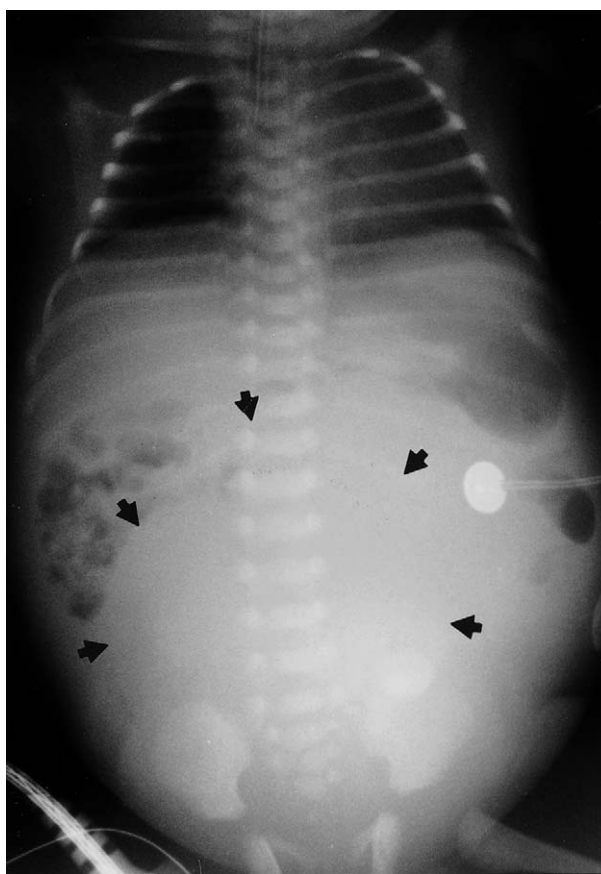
Abdominal radiograph of a newborn baby with a cloaca and a very large hydrocolpos.
